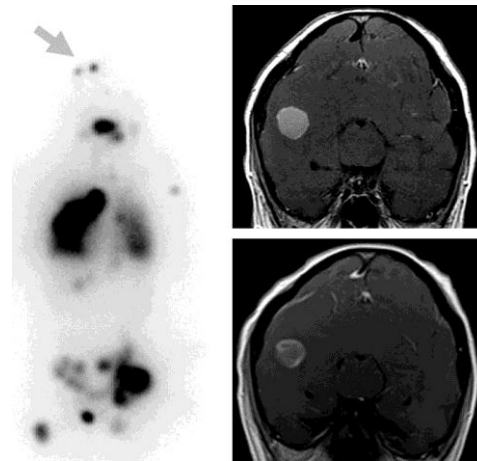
Anterior planar imaging (left image) from head to upper thigh after administration of radioiodine demonstrates widespread metastatic disease in the brain, lungs, and skeleton. Arrow indicates brain metastases. MRI post GBCA in the coronal plane prior to therapy (top right) demonstrates a homogeneously enhancing metastasis (orange circle). MRI post GBCA in the coronal plane after therapy with iodine-131 (bottom right) demonstrates decreased enhancement of the metastasis (orange circle) consistent with partial response.
